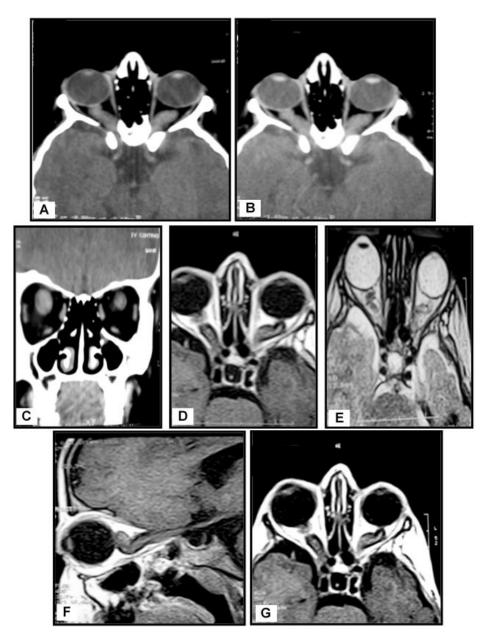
Bilateral optic nerve glioma. A 14-year-old female patient presented with diminution of vision and Proptosis at both eyes. CT Examination: (A) Axial Cuts show marked enlargement, kinking and buckling of both optic nerves with a widening of both optic foramina. (B) and (C) Post-contrast axial and coronal cuts of the same patient show mild homogeneous enhancement. MRI Examination: (D) Axial T1-WI of the same patient shows both enlarged optic nerves displaying an isointense signal. (E) Axial T2-WI of the same patient shows an isointense signal of the lesion. (F) Post-contrast sagittal oblique T1-WI of the same patient reveals enlargement, kinking and buckling of the right optic nerve with mild enhancement. (G) Post-contrast axial T1-WI of the same patient shows mild enhancement.
